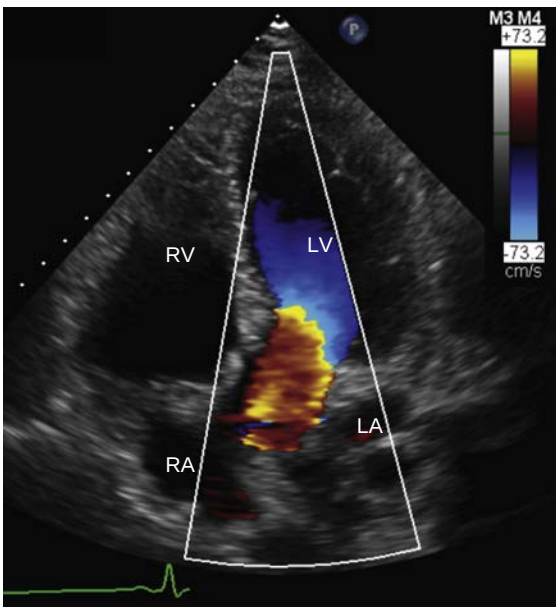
Color Doppler with signal aliasing. This color Doppler image of LV outflow in an anteriorly angulated apical 4-chamber view shows signal aliasing adjacent to the septum in the subaortic region. Although this appearance may be due to an asymmetric flow profile, the effects of intercept angle also may be important. Even if the velocity is identical across the outflow tract, compared with the region along the anterior mitral valve leaflet, the region adjacent to the septum the Doppler beam is more parallel to the flow direction. The higher Doppler shift results in signal aliasing. Aliasing at the aortic valve level is expected because the aortic velocity typically exceeds the Nyquist limit at this depth (0.73 m/s in this example).
